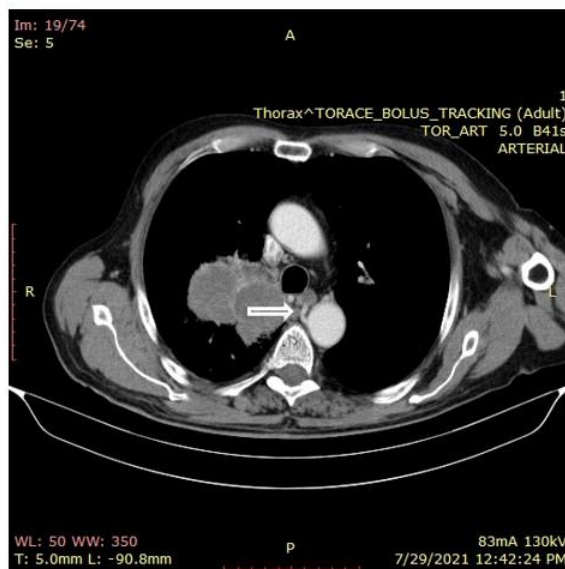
CT *spect* showing right *upper* lobe mass and enlarged right bronchial artery [arrow]
